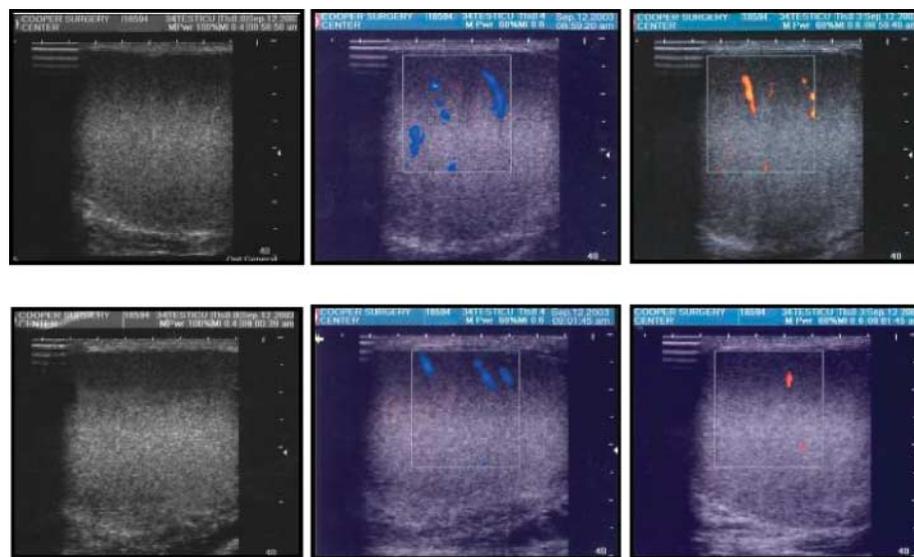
Analysis of testicular structure using Doppler ultrasonography. Typical paired pre- and post-operative images are shown. Grey scale study demonstrates the homogeneous pattern pre-biopsy (A) and the unchanged pattern post-biopsy (D), colour Doppler demonstrates the position of the major intratesticular vessels before biopsy (B) which are unchanged post-biopsy (E), and the power Doppler images demonstrate tissue perfusion pre-biopsy (C) which is unchanged post-biopsy (F). (A–C) Ultrasound appearance pre-biopsy. (D–F) Ultrasound appearance 2 months after biopsy.
